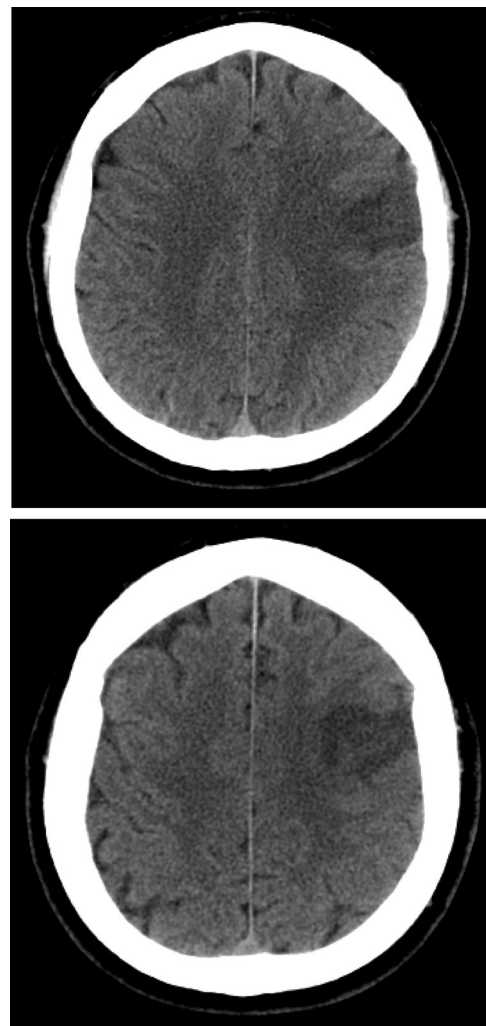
CT shows left hemispheric damage located within the frontal lobe, near fronto-parietal junction.
